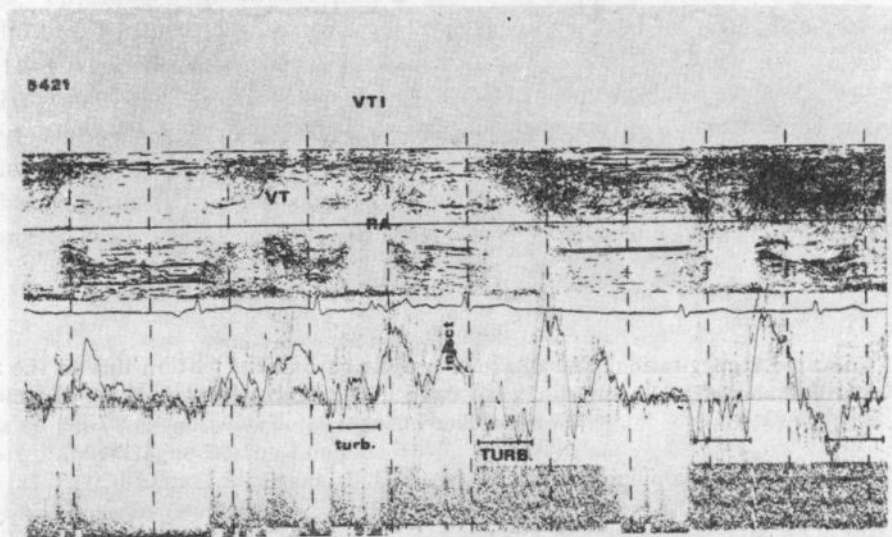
Tricuspid regurgitation (VTI). The typical Doppler changes due to the regurgitant microbubbles towards the right atrial outflow tract-RA (sample volume under the echo of anterior tricuspid leaflet VT)
